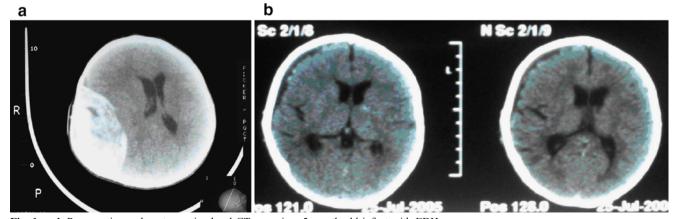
a, b Preoperative and postoperative head CT scans in a 5-month-old infant with EDH
